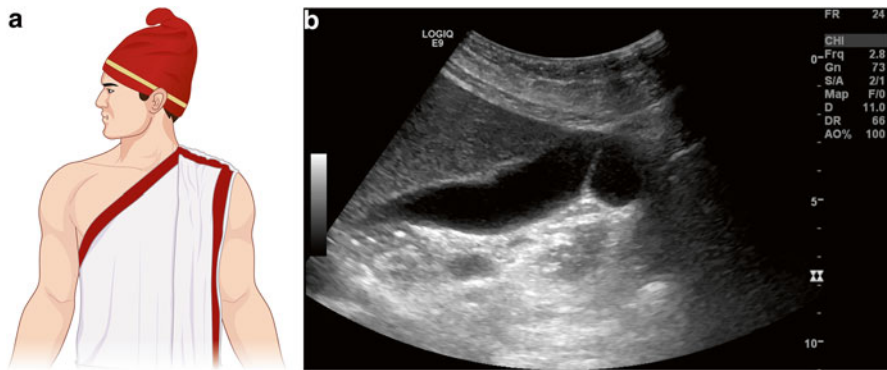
(a, b) The Phrygian cap is a normal variant found on gallbladder ultrasonography. Here a picture of a person wearing a Phrygian cap (a) is compared to the ultrasonographic finding (b)
